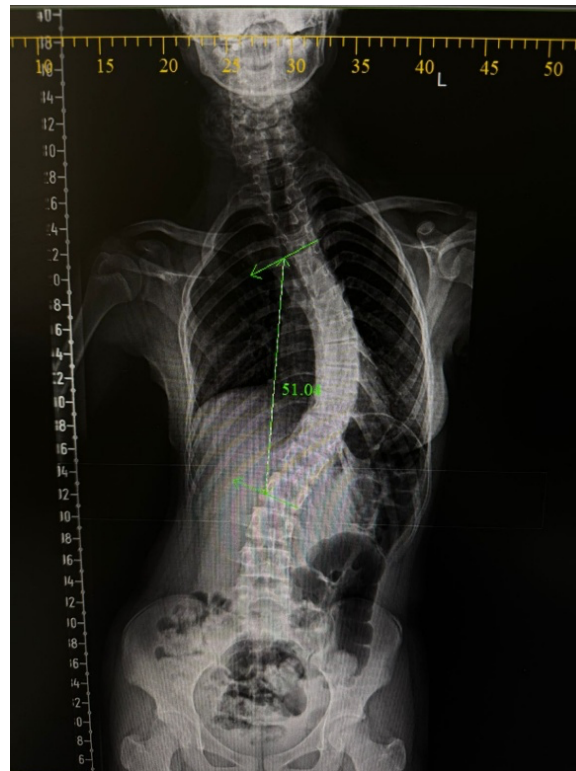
Standing AP radiograph demonstrating Cobb angle measurement.
